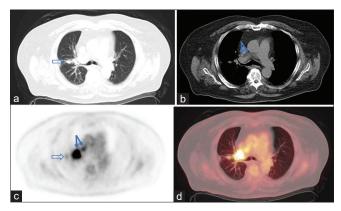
A 76-year-old man with new-onset nystagmus, altered mental status, and unsteady gait. Brain magnetic resonance imaging (not shown) was without acute abnormality. (a) CT scan shows a small right upper lobe nodule (open arrow), and (b) lymphadenopathy in the right hilum and mediastinum (arrows). (c and d) <sup>18</sup>F-FDG PET/CT scan shows moderate uptake in the lung nodule (open arrow) and intense uptake in the hilar and mediastinal lymph nodes (arrows). Biopsy of lymph node revealed metastatic small cell lung carcinoma
